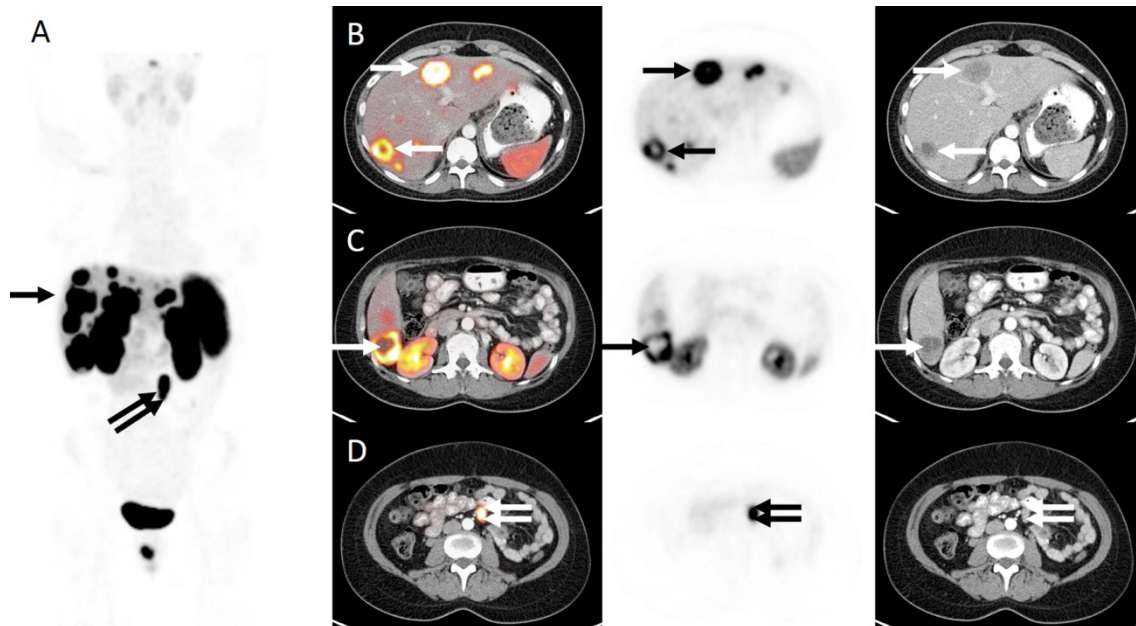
38-year-old female patient with metastatic NET of unknown primary. Octreoscan revealed SSTR-positive liver metastases. No extrahepatic disease was noted. The intended management was somatostatin-analogue therapy. Maximum-intensity projection (A) and axial images of ^{68}Ga -DOTATATE PET/CT performed two months after Octreoscan are shown. PET/CT revealed numerous liver lesions (rows B, C) with intense tracer uptake (arrow). In addition, a left mesenteric mass was discovered (row D, double arrow), which was later confirmed to be a small bowel primary. Surgery for the small bowel primary and initiation of somatostatin-analogue therapy was implemented two months after ^{68}Ga -DOTATATE PET/CT scan.
